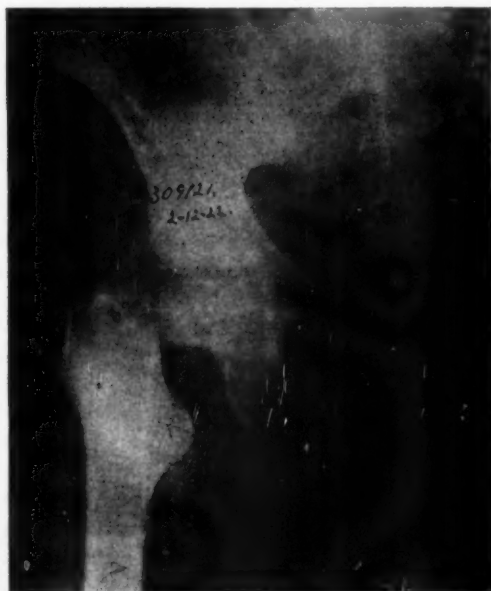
(Case 1). (a) Fracture of the neck of the femur. (b) After reduction, showing anatomic reposition. In (b) the roentgenogram was taken through plaster-of-Paris cast.
